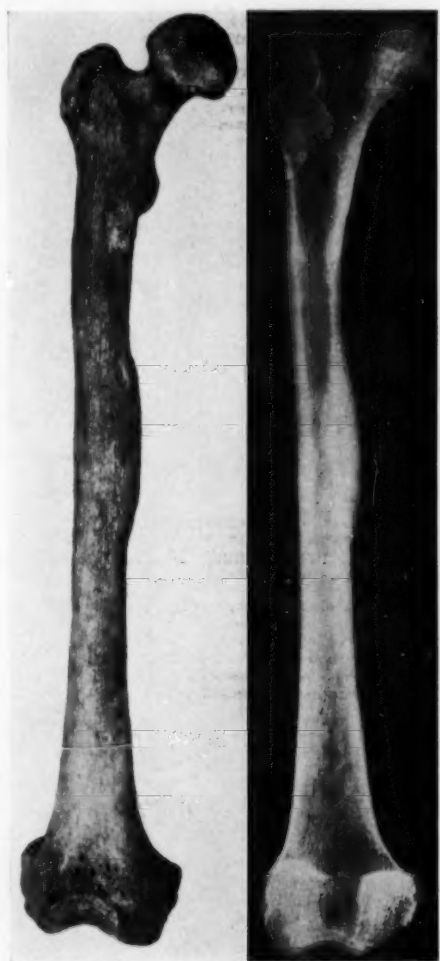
Pecos case 60455, right femur (original photograph). The roentgenogram was made by Dr. E. C. König, of the Buffalo General Hospital.
